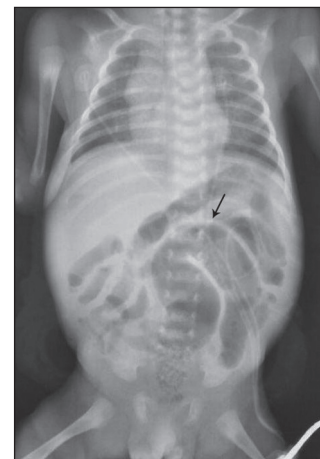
Plain abdominal X-ray showing distended bowel loops floating on ascitic fluid. A small bowel or sigmoid loop was suspected to be twisted (arrow)
